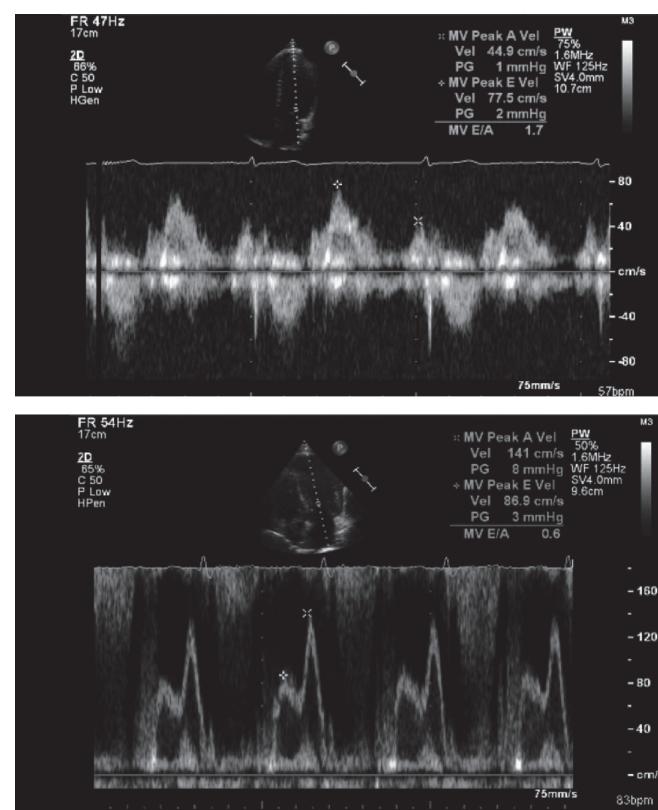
Exemplar Doppler transmitral flow images taken from an athlete. (a), note the E/A ratio of 1.7, and a patient with hypertrophic cardiomyopathy (b), note the reversed E/A ratio of 0.6.
